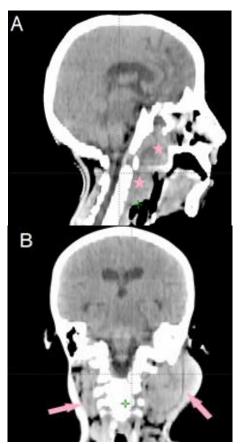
Axial (A) computed tomography slide shows the primary nasopharyngeal carcinoma with its extensions. and coronal slide (B) demonstrating bilateral cervical lymph nodes metastases.
